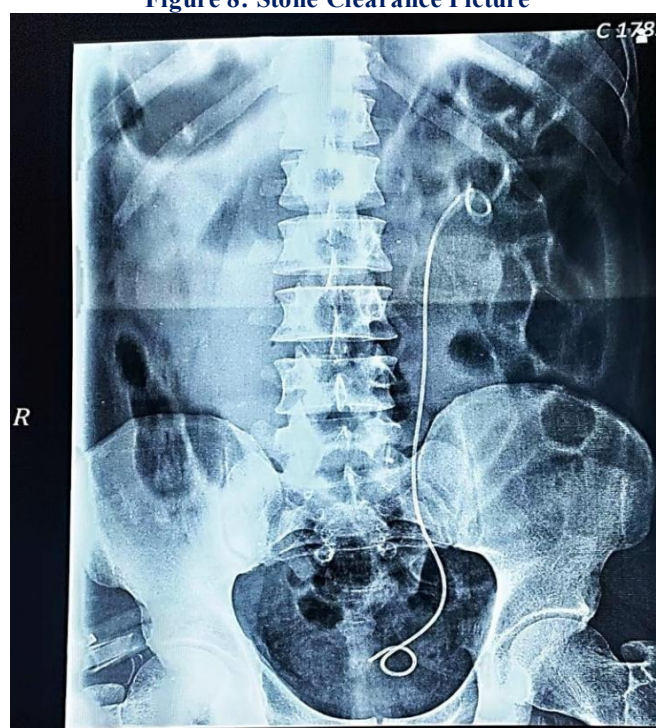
Post-Operative X-Ray KUB showing left DJ Stent in situ.
